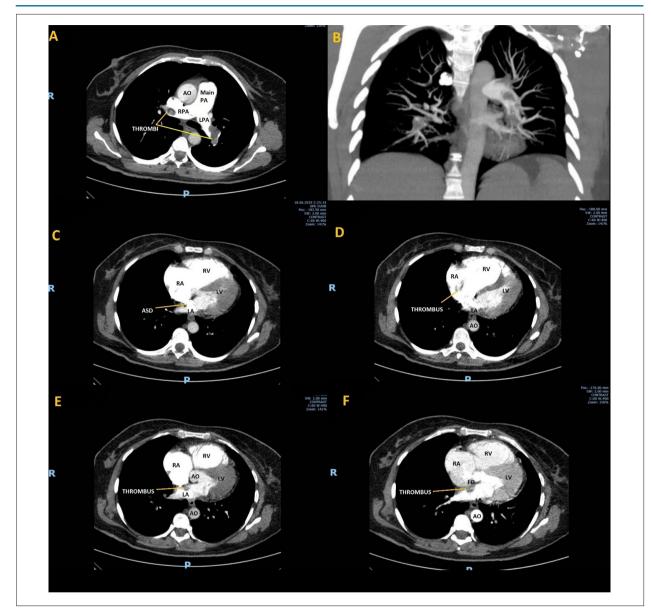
Thoracic computed tomography. Panel A – transversal section showing massive pulmonary embolism with thrombus in the main left and right pulmonary arteries. Panel B – Reconstruction image showing occlusion of the main pulmonary arteries and peripheral oligoemia. Panel C – transversal section showing the atrial septal defect with the contrast substance flowing from the right atrium to the left atriums. Panel D – transversal section showing the thrombus in the right atrium. Panel E – transversal section showing the thrombus extending to the left atrium. Panel F – transversal section showing the thrombus in the fosa ovalis. PA: pulmonary artery; RPA: right pulmonary artery; LPA: left pulmonary artery; AO: aorta; RV: right ventricle; RA: right atrium; LV: left ventricle; LA: left atrium; ASD: atrial septal defect; FO: fosa ovalis.
